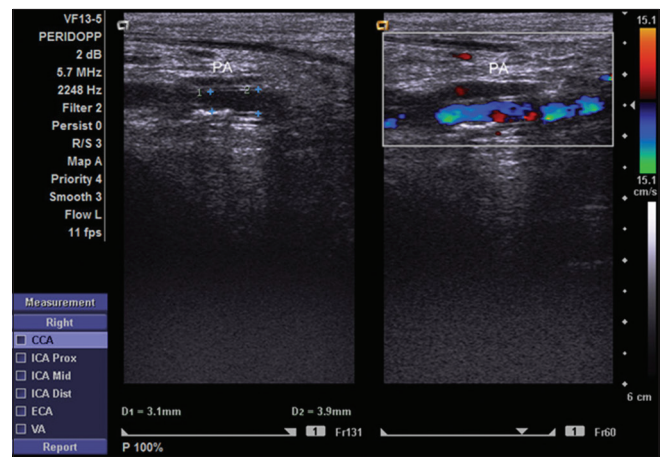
Longitudinal grayscale and color Doppler images of popliteal artery with mild stenosis showing turbulent color flow at site of stenosis
